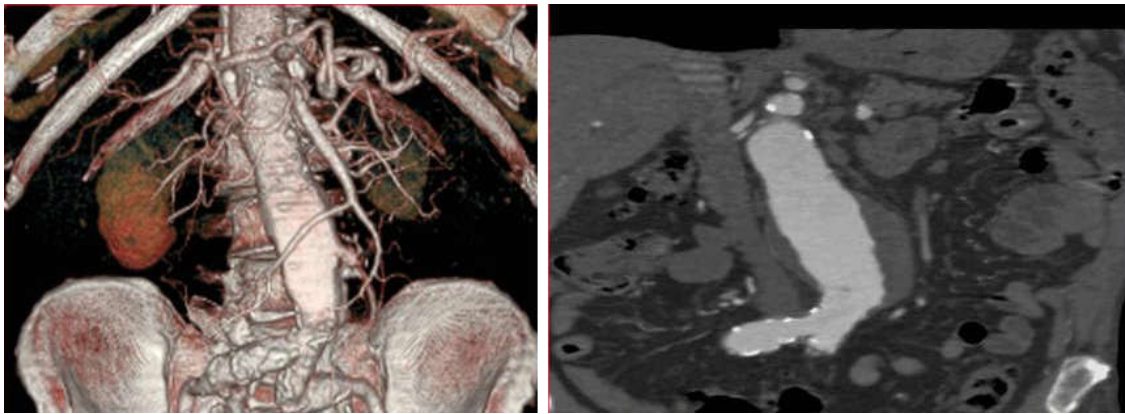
Volume rendering example (left) from a CT dataset (right).
